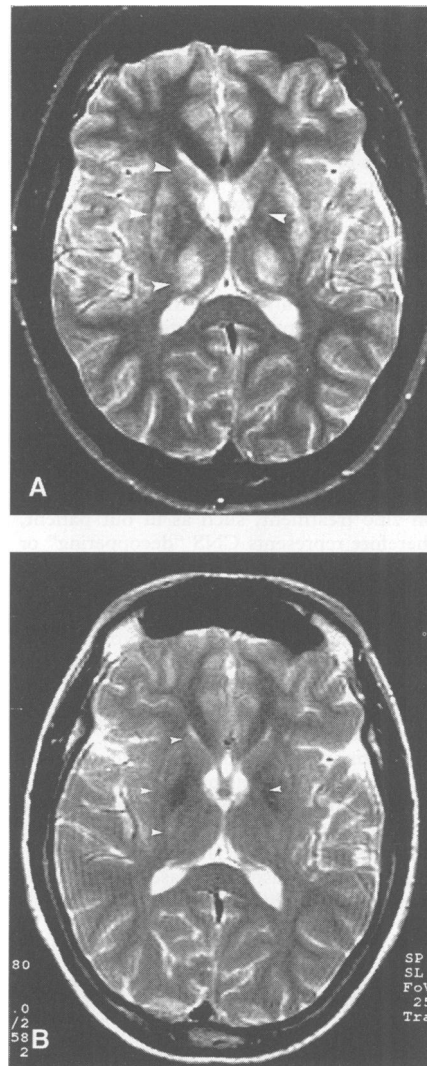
Axial T2 weighted (TR 2300: TE 105) MRI. (A) Bilateral hyperintense lesions in the thalamus, striatum, and pallidum (arrows); (B) After 16 months on zinc sulphate treatment the lesions have largely resolved (arrows).
